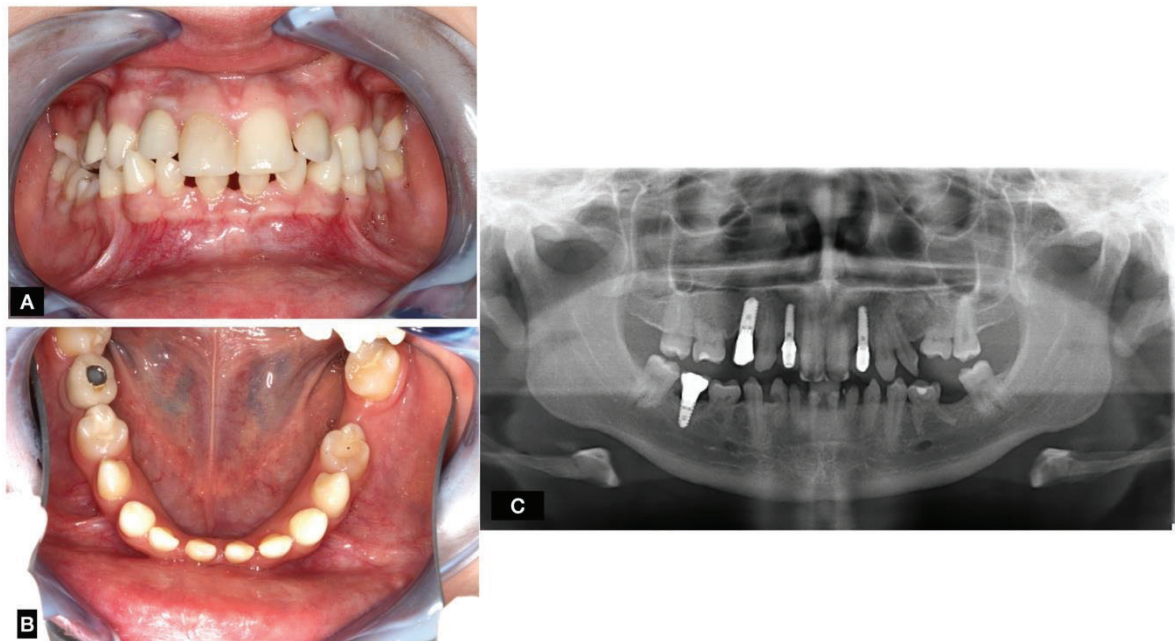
Clinical case with an unsuccessful dental implant in the right mandibular first molar region according to Albrektsson and Buser: A–B) intra-oral photos; C) panoramic x-ray. Subjective assessment of patient satisfaction is missing. Clinical case of the Department of Oral and Maxillofacial Surgery, University Hospital Giessen.
